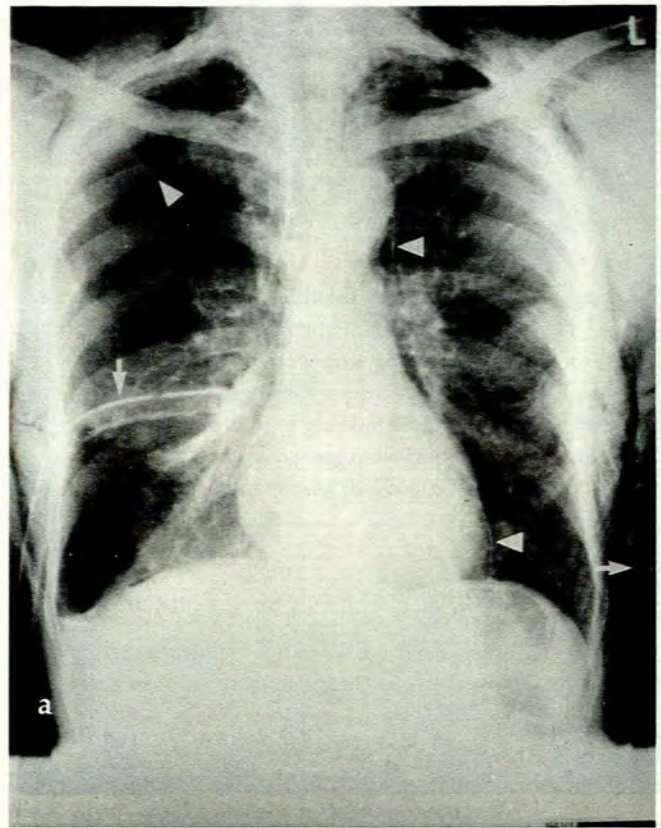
Conventional (a) and digital (b) radiographs in a patient following a stab wound to the chest, showing pneumothoraces (arrowheads) and intercostal chest drains (short arrows), with the left misplaced in the subcutaneous tissues. Note that the right apical pneumothorax is not visible on the digital radiograph. Retrocardiac structures are better visualised on the digital image. Also present is extensive surgical emphysema.
